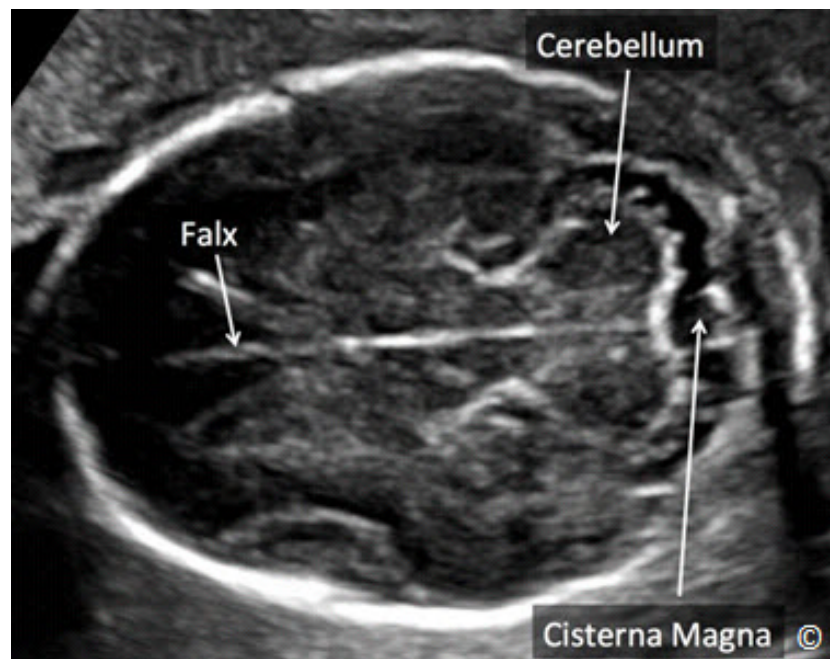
Transverse plane of the fetal head at the level of the posterior fossa. Sonographic landmarks include the cerebellum, cisterna magna and falx (labeled).
